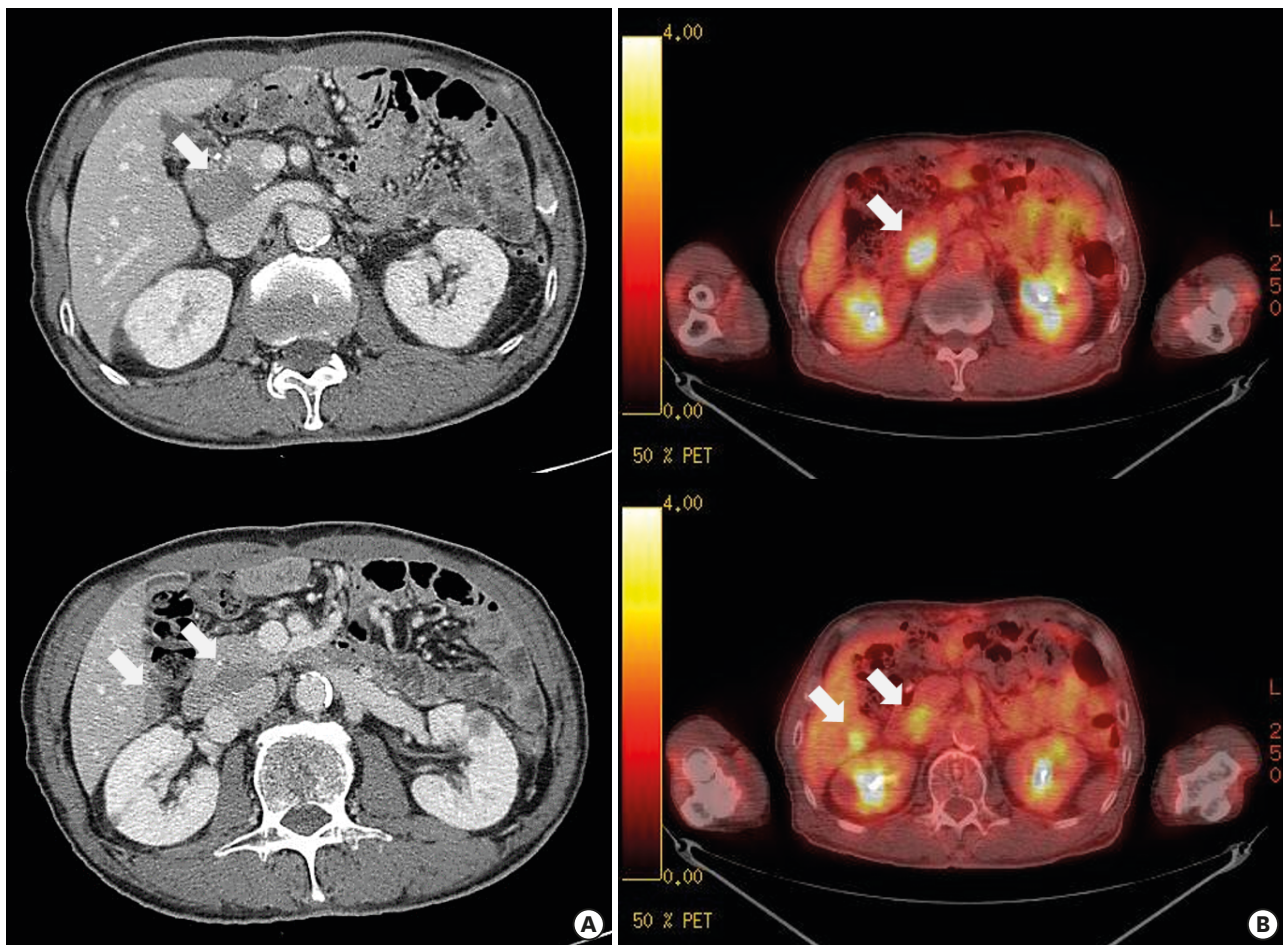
CT and PET scans at first recurrence to the intra-abdominal LNs. (A) CT of the abdomen revealed well-defined enhancing masses in the peripancreatic area and inferior aspect of the right lobe of the liver. (B) PET revealed ^{18}F -FDG uptake in the peripancreatic area and inferior aspect of the right lobe of the liver (standardized uptake values, 6.1 and 3.3, respectively).
